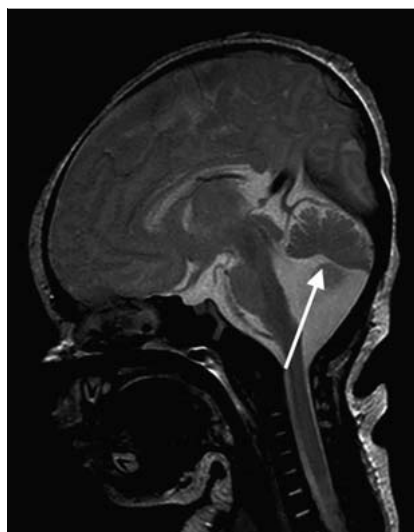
Neonatal MRI: sagittal T2-weighted image shows hypoplasia of the vermis with malrotation.
